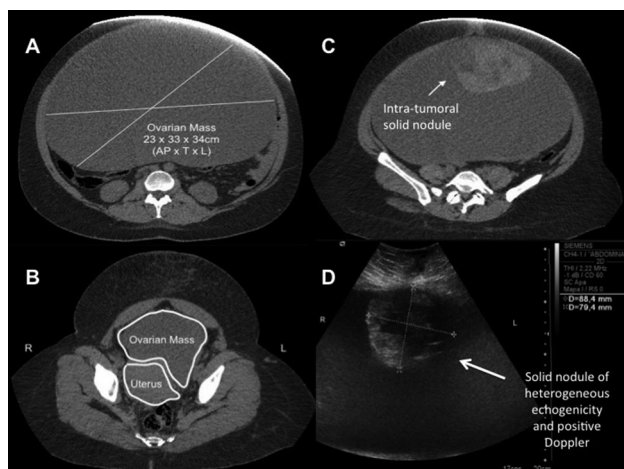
CT scan: a unilocular cystic tumor of left adnexal origin that occupies the whole abdominal cavity (A). The uterus is lateralized to the right (B), and the tumor contains a solid nodule suspicious for malignancy (C, D).
